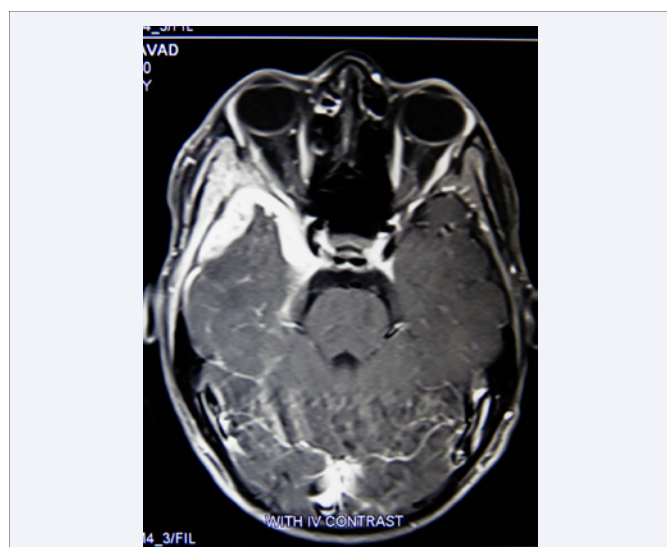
MRI reveals mucosal thickening and destruction of right maxillary sinus wall, with involvement of dura mater in the right middle cranial fossa and right cavernous sinus.
